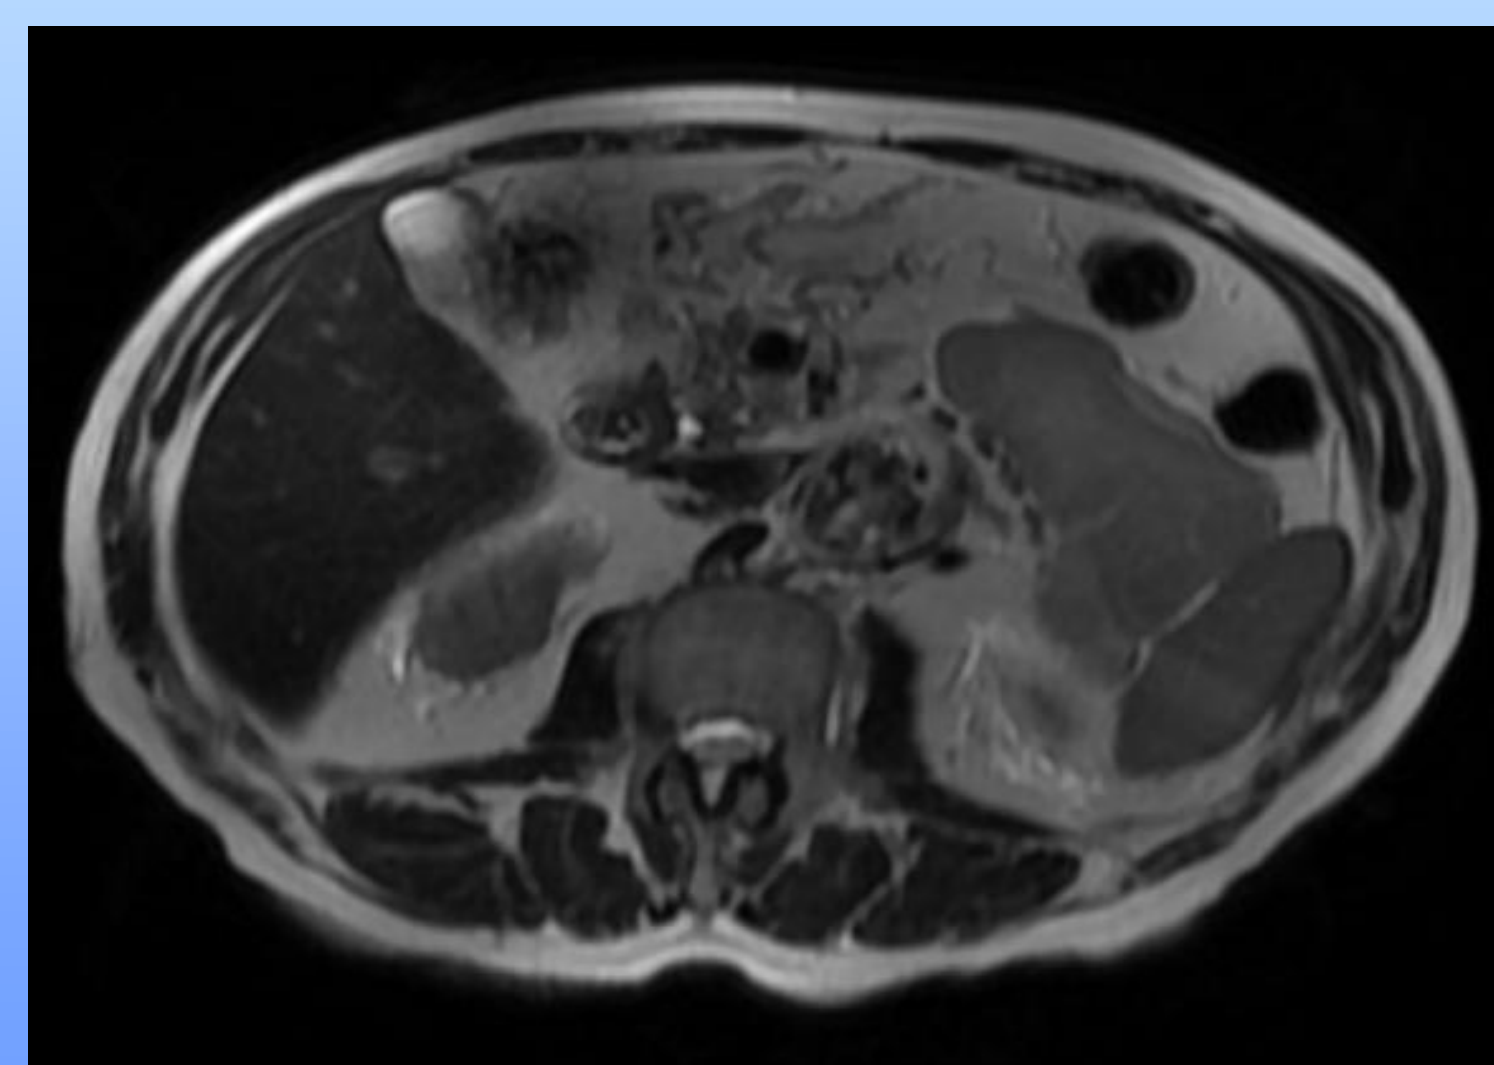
MRI Showing 90mm cyst
